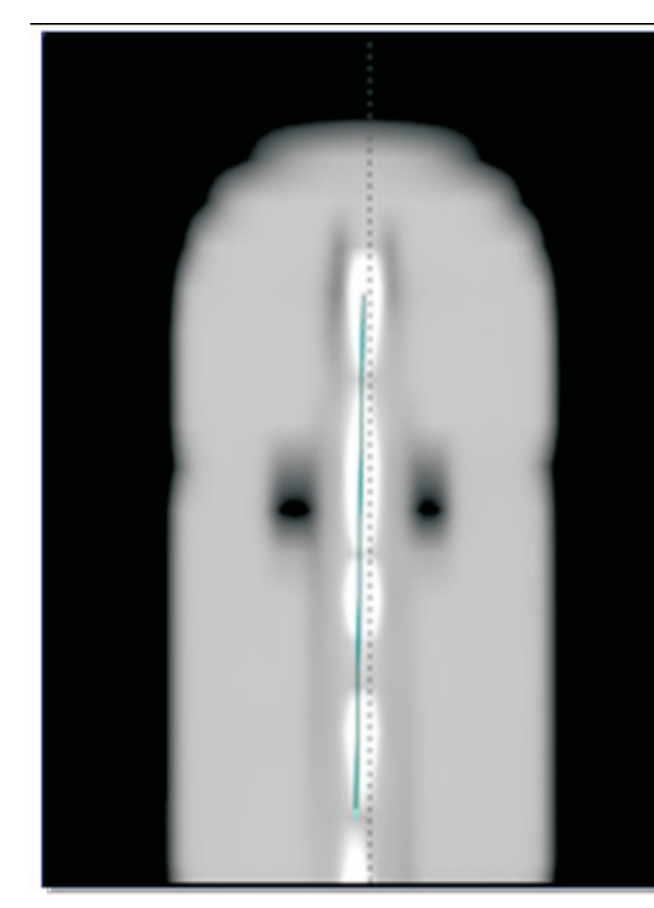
Shallow ogive's digitally reconstructed radiography
